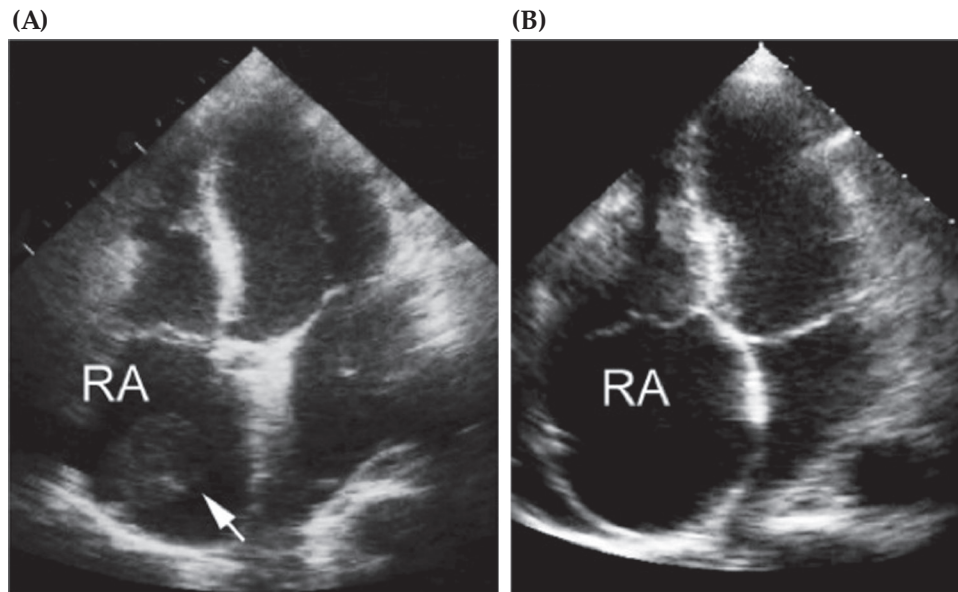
Right atrial thrombus showed by echocardiography in a 45-year-old BD man with concomitant deep-vein thrombosis [170] (Panel A). Panel B shows the complete resolution of the thrombus 2 months after initiation of immunosuppressive therapy with high-dose steroids and cyclophosphamide. Adapted from Kuno et al. [170].
